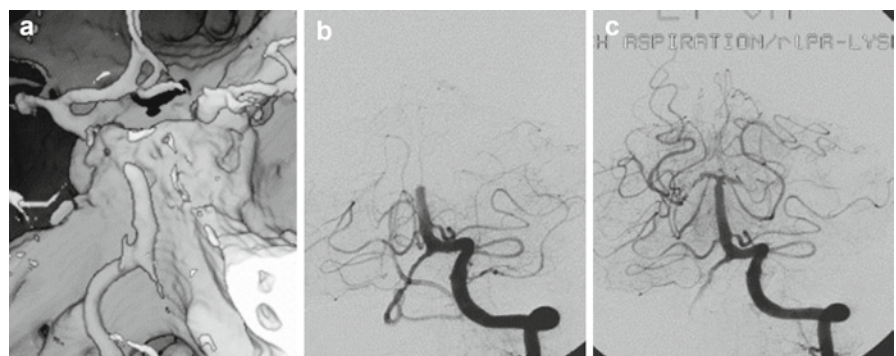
Recanalization of an acute distal basilar artery occlusion. CTA (a) and DSA before (b) and after (c) recanalization. After only partially successful lysis with 10 mg rTPA, the residual (suspected embolic) material was aspirated via vertebral artery catheter. Residual posterior cerebral artery stenosis, *right*, and occlusion due to floated off emboli, *left*
